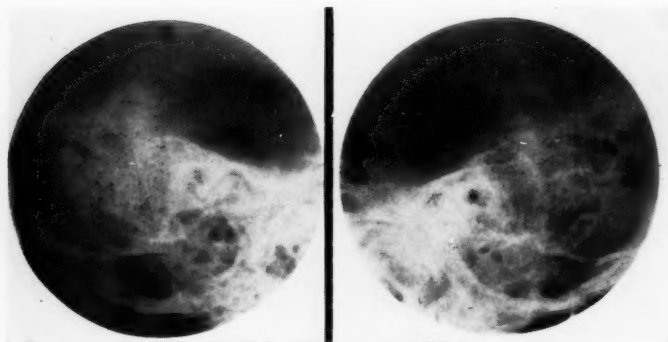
Roentgenograms right and left mastoids.
